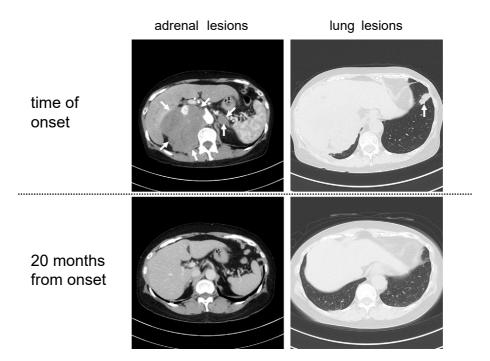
Case 2: CT scans before and after methotrexate termination.
